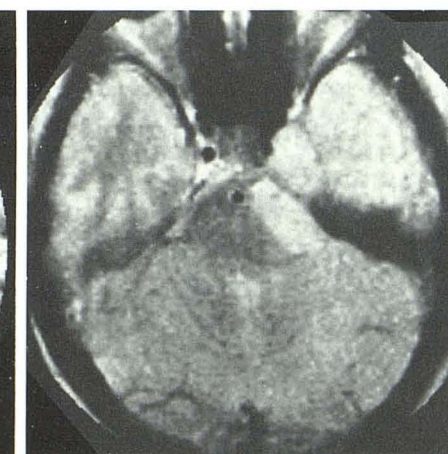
A–E, Case 4. Trigeminal lipoma of right trigeminal nerve and Meckel's cave demonstrates high signal intensity (arrow) on T1-weighted images (A–D, 3050/500) and intermediate signal intensity on T2-weighted image (E, 2150/100), similar to the subcutaneous fat. Note trigeminal nerve root (arrow) in C and involvement of mandibular division (arrow) in D. Reprinted from [6].
